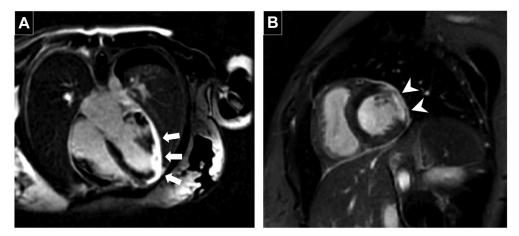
Cardiac magnetic resonance imaging. (A) Four-chamber view shows diffuse LGE more prominent at both the visceral and parietal pericardium, as well as basal anterolateral, apical lateral, and apical segments. The basal lateral and apical lateral segments show areas of transmural hyperenhancement (*arrows*). (B) Short-axis view shows patchy transmural hyperenhancement of the mid anterolateral segment, with LGE of adjacent pericardium (*arrowheads*).
